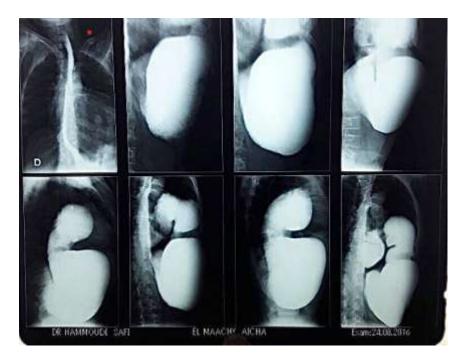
x-rays chest (intra thoracic aerial image)
